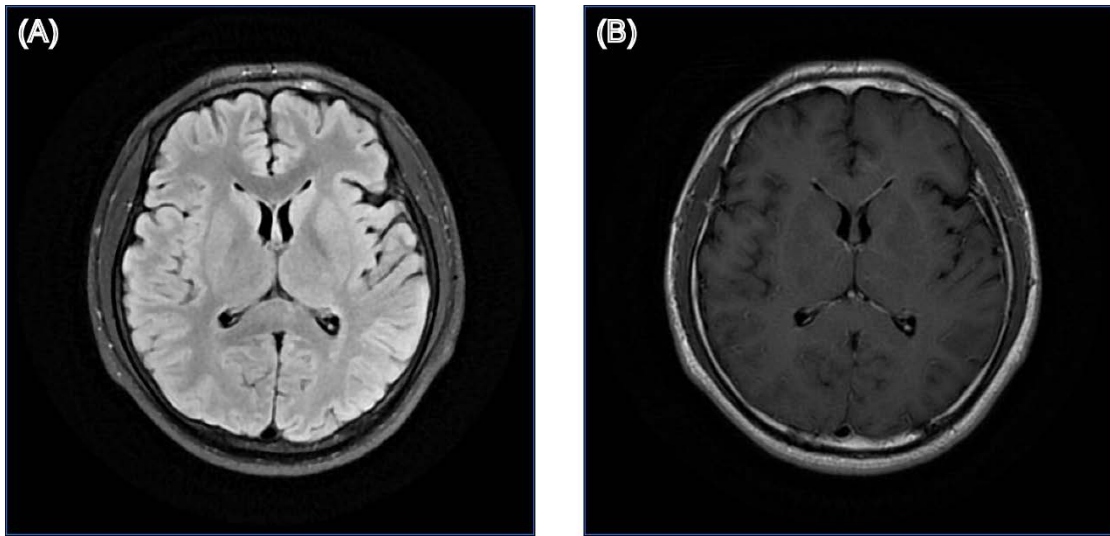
Structural brain MRI images of patient 17. (A) T2-weighted fluid-attenuated inversion recovery (T2-FLAIR) image; (B) Gadolinium-enhanced T1-weighted (Gd-T1w) image.
